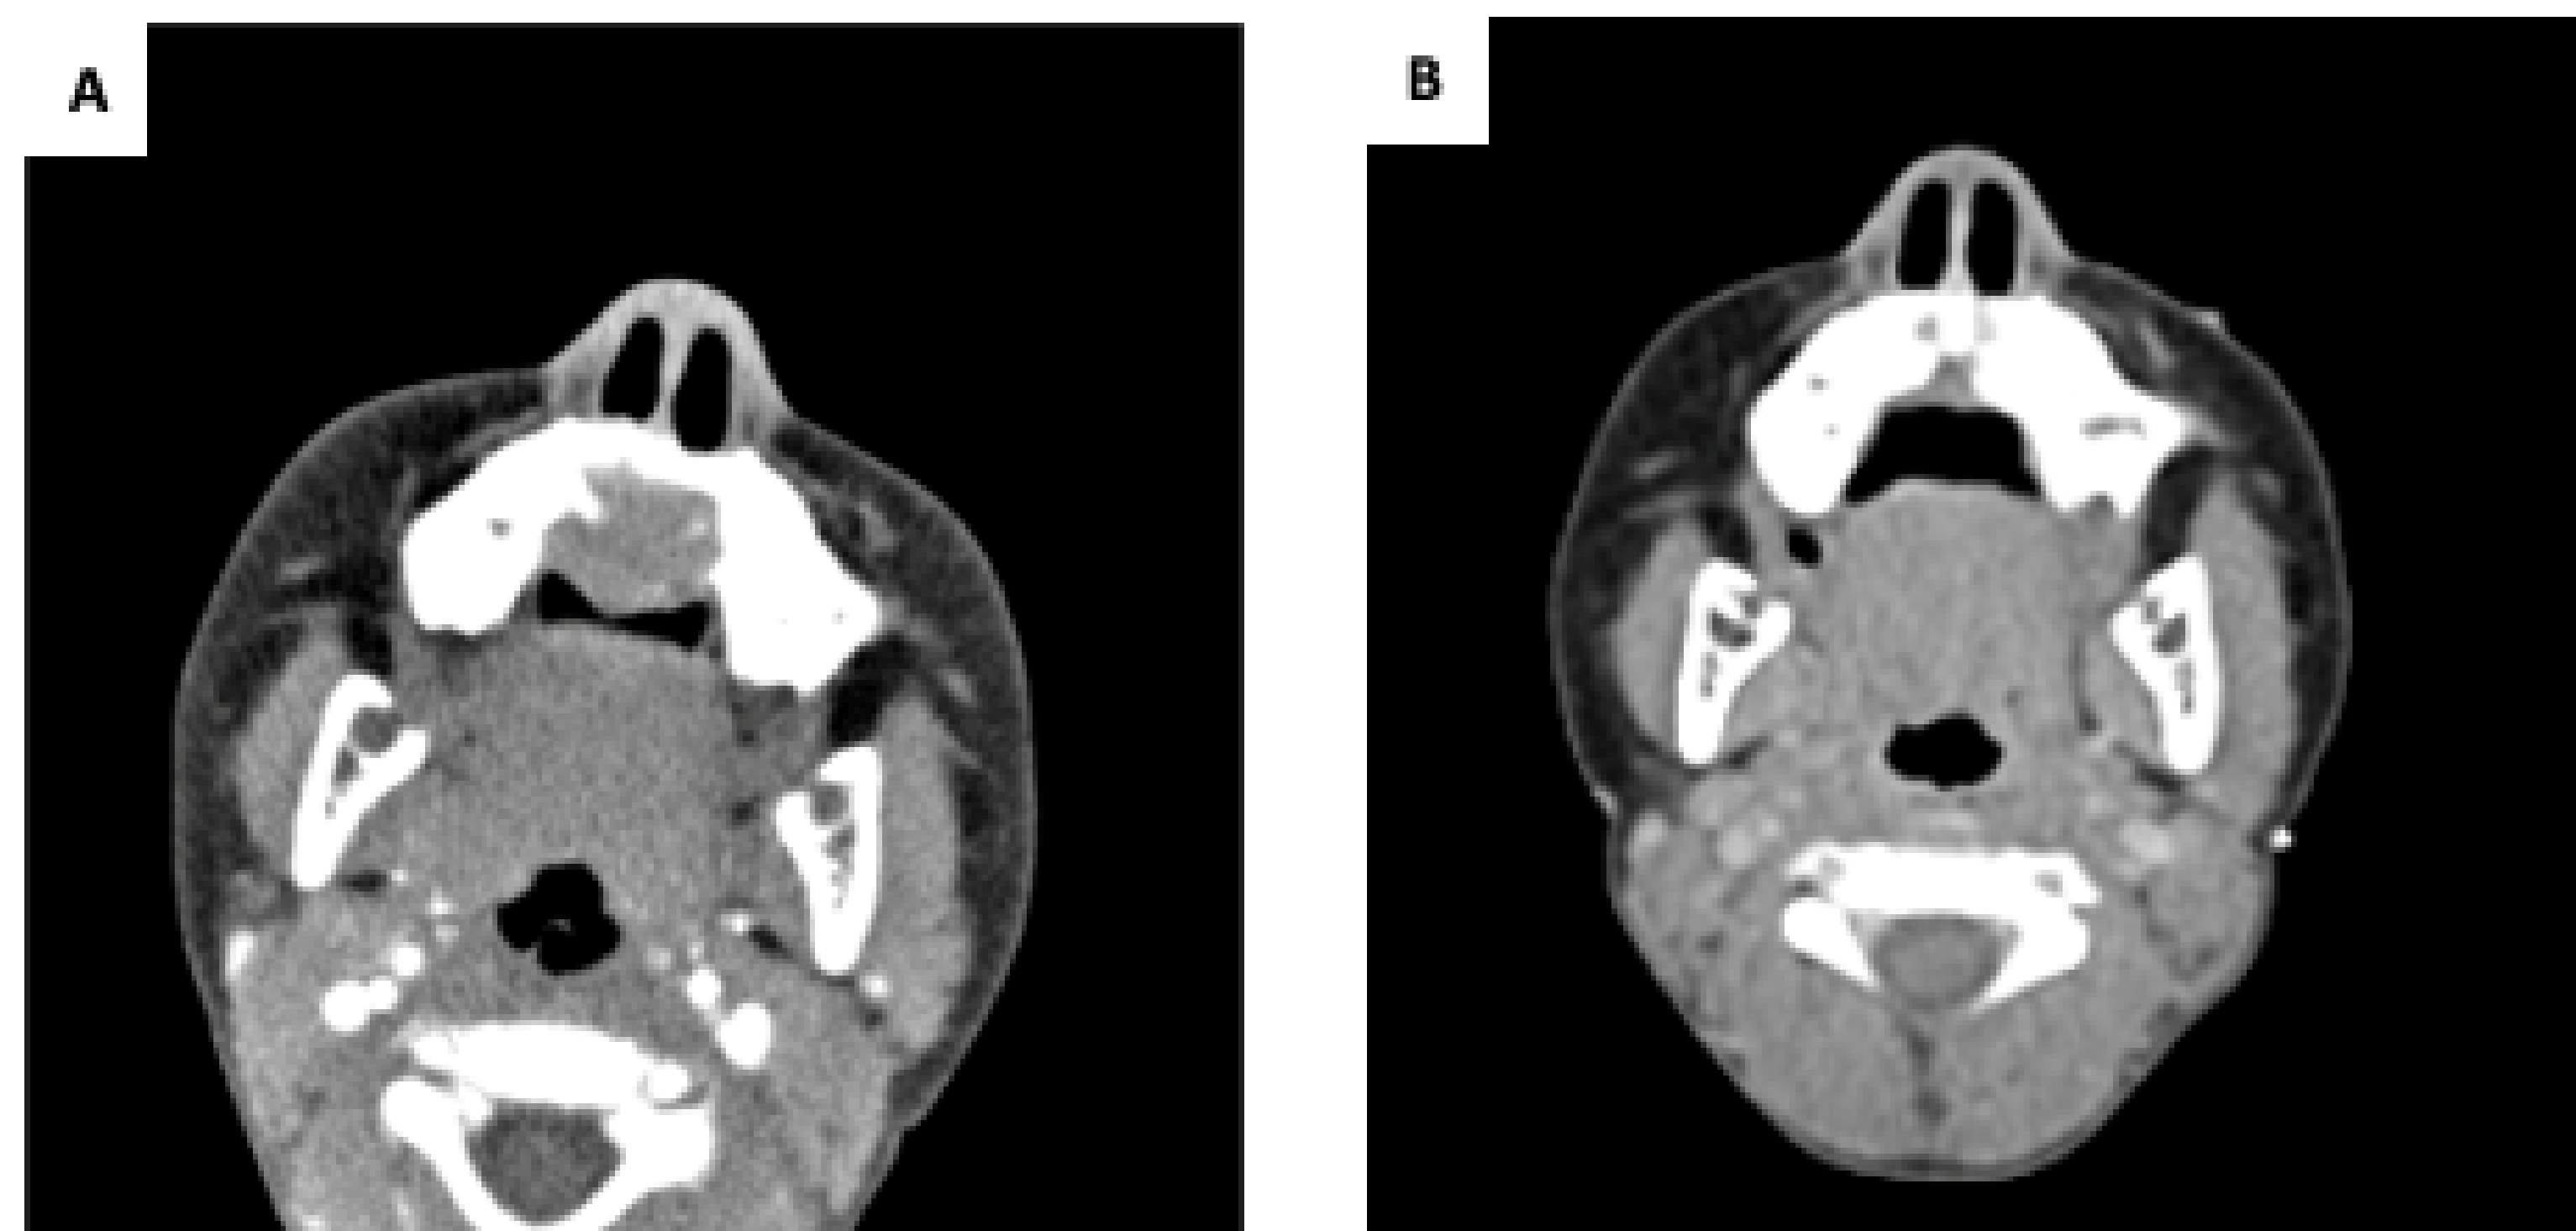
A: Computed tomography, pre-treatment, demonstrating an erosive mass at the anterior palate, extending into the inferior nasal cavity. B: Computed tomography, 1.5 months into treatment and approximately 8.5 months from Image A.
